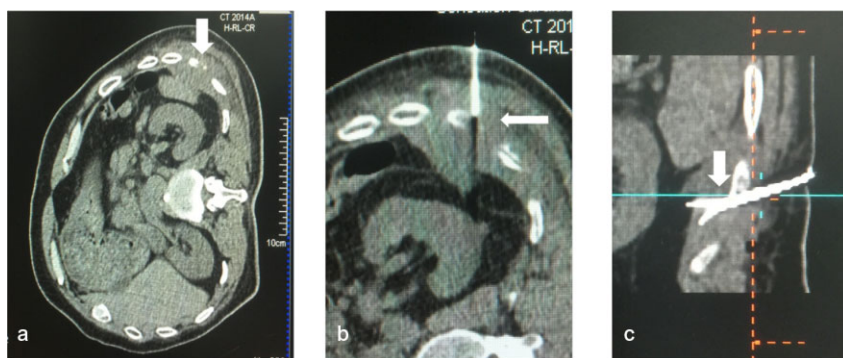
(a) A 73-year-old male patient, three years after a pneumonectomy for left upper lobe squamous carcinoma T3N0M0. A pre-procedural computed tomography scan was performed to locate the lesion (34 mm in maximum axis); the metastasis invaded the left 10th rib (arrow). (b) The needle tip (arrow) was accurately placed on the lesion to perform a biopsy for gene analysis. (c) An RFA needle was placed into the target lesion particularly aimed at the intercostal nerve area (arrow).
